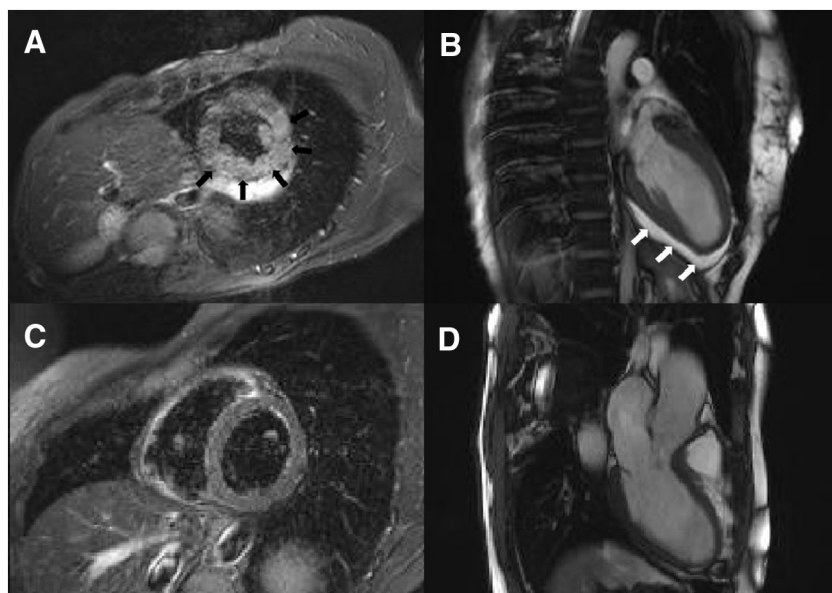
Cardiac magnetic resonance imaging (cMRI). A. STIR short axis plane - increased intensity of the lateral, inferior and posterior wall of the left ventricle (black arrows); B. 2-dimensional (2D) TOF sagittal images showing mild to moderate pericardial effusion (white arrows); C–D. Follow-up cMRI sequences showing complete regression of myocardial lesions.
